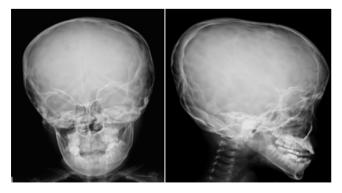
These simple skull x-rays show enlarged skull with increased convolutional markings of skull and hypoplasia of facial bones.
